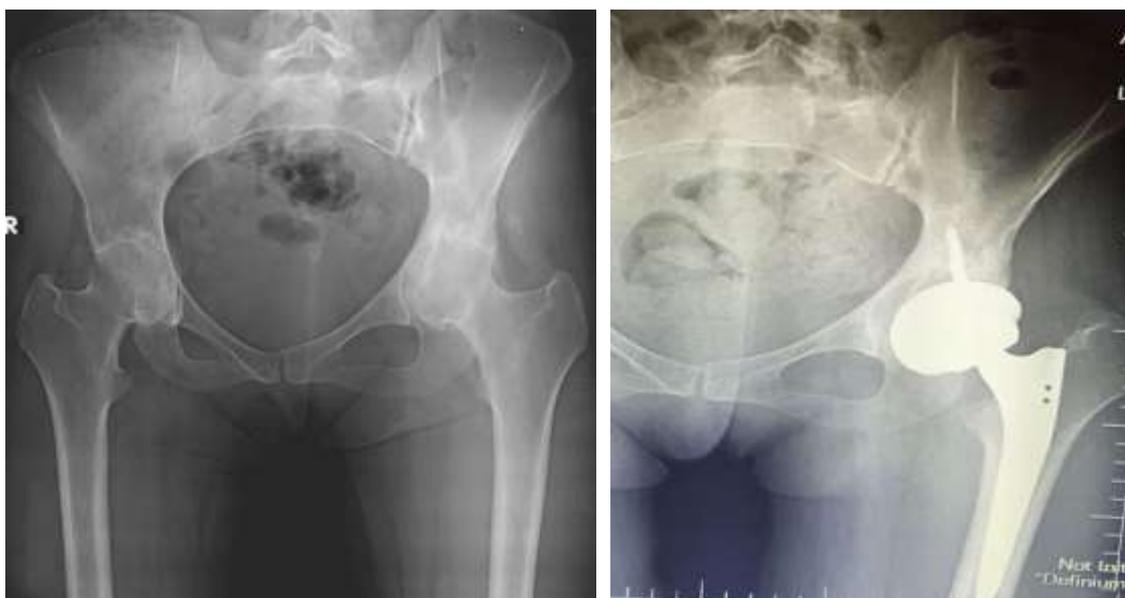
A) 21-year-old female patient with a history of Sjögren's disease: preoperative AP radiograph. B) A 21-year-old female patient with a history of Sjögren's disease total hip arthroplasty performed 2 years ago using SL-MIA.
